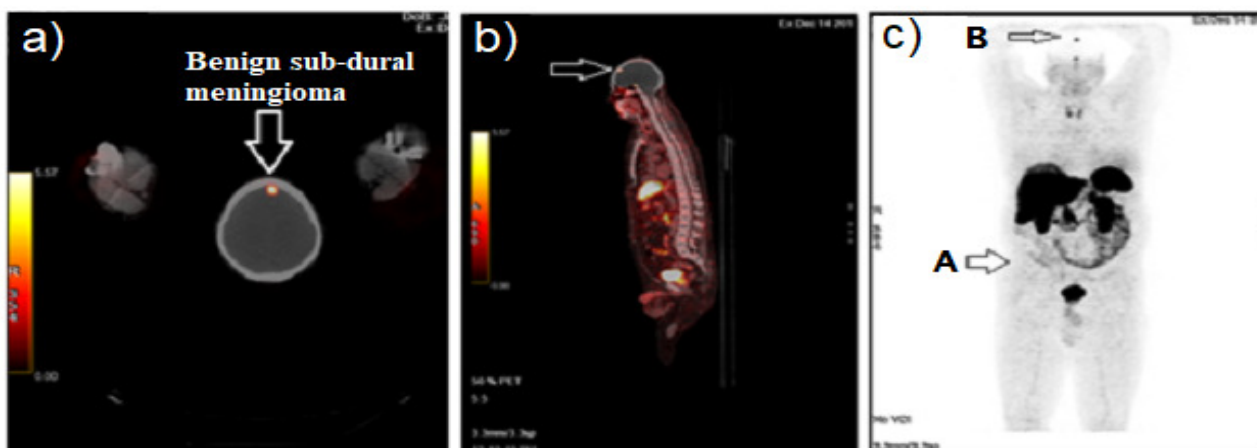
^{68}Ga -DOTANOC PET/CT showing a) axial fused PET-CT, b) sagittal view of fused PET-CT; the arrow in both scans showing the uptake by benign sub-dural meningioma, c) show the anterior view of maximum intensity projection (MIP) image with A showing the clearance of malignant tumor and B showing the benign sub-dural meningioma.
